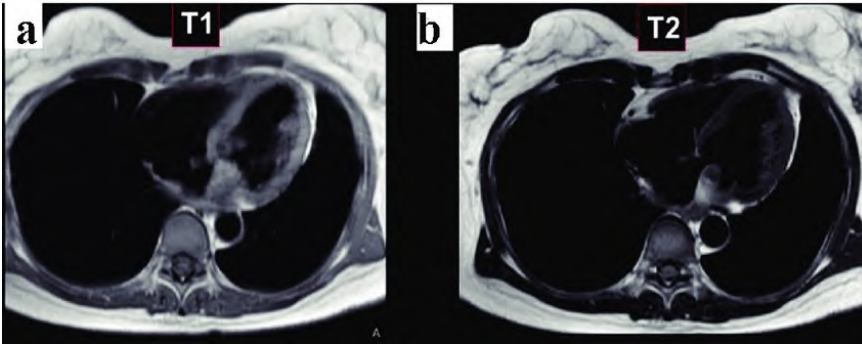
Examples of cardiac MRI scans. Heart of a patient with sarcoma in the left atrium. a) T_1 -weighed. b) T_2 -weighed. Adapted from the reference: A Rare Cause of Dyspnea: Undifferentiated Pleomorphic Sarcoma in the Left Atrium - Scientific Figure on ResearchGate. Available from: https://www.researchgate.net/figure/Cardiac-MRI-Both-tumors-are-isointense-in-T1-weighted-black-blood-imaging-a-The_fig4_320679672 [accessed 20 Oct, 2019] via license: Creative Commons Attribution-NonCommercial 4.0 International [54].
